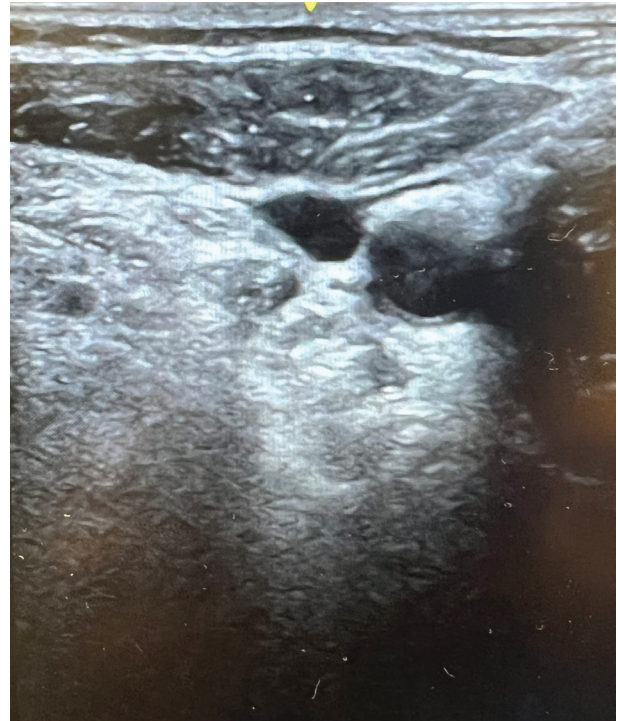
Ultrasound image of peripheral nerve stimulator lead placement for ulnar and median nerve of the right upper extremity.
